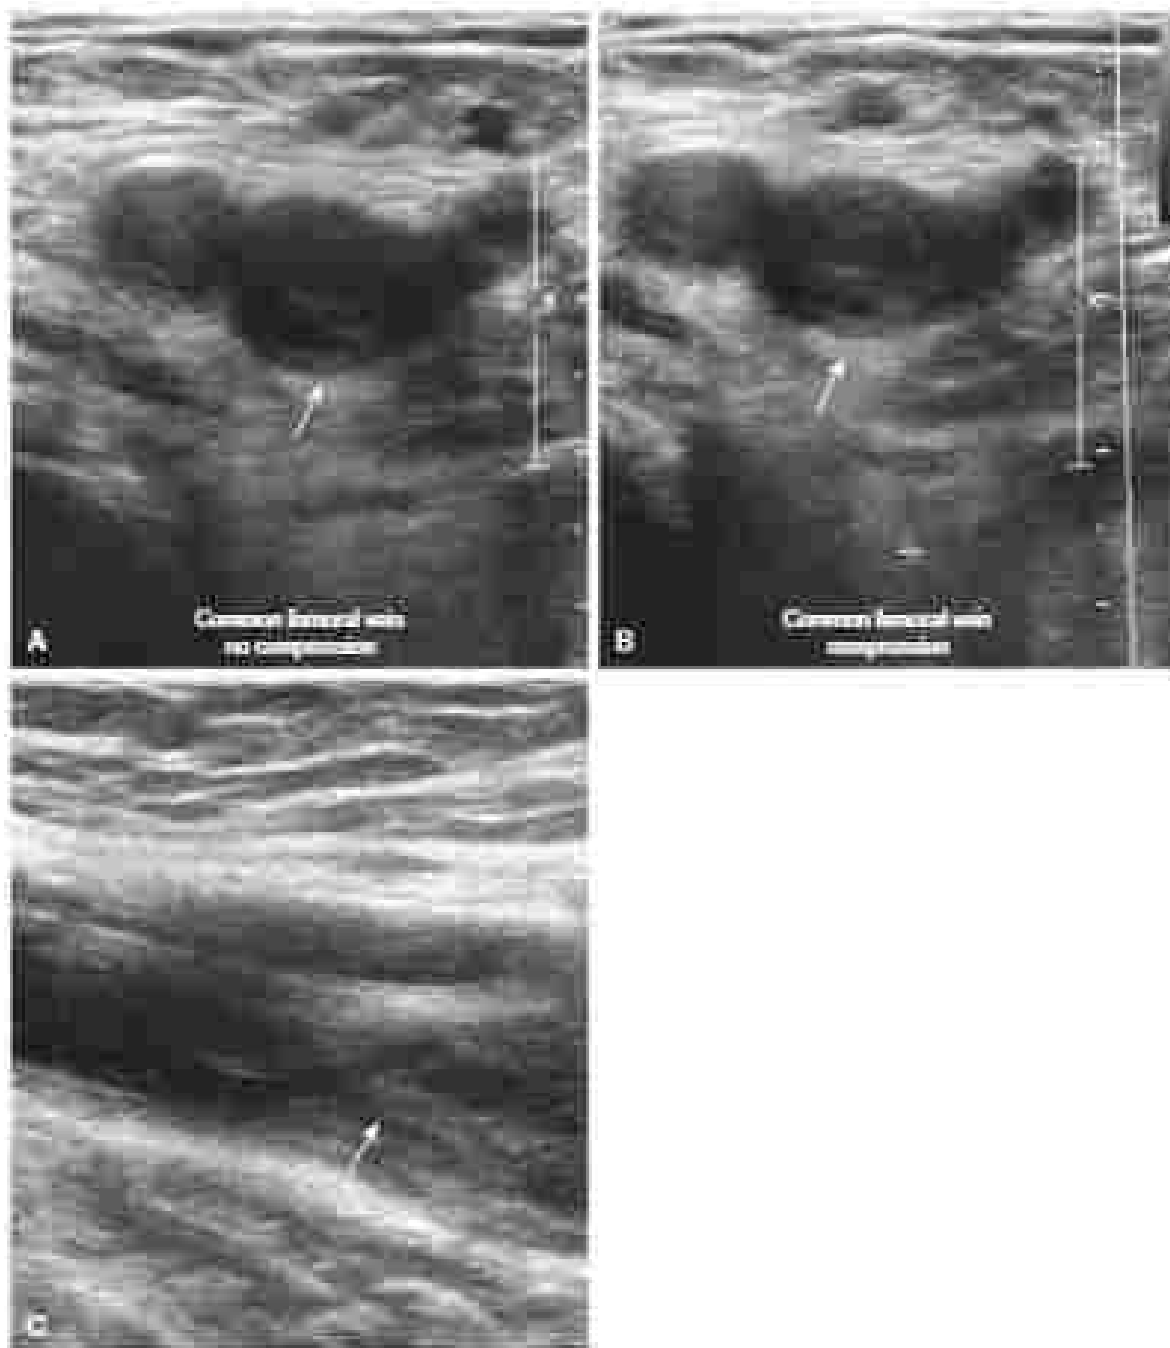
(A) Cross-sectional venous ultrasound image showing noncompressibility and increased diameter (arrow). (B) Compression view. (C) Longitudinal ultrasound image of the common femoral vein with manual (thimble) pressure.
